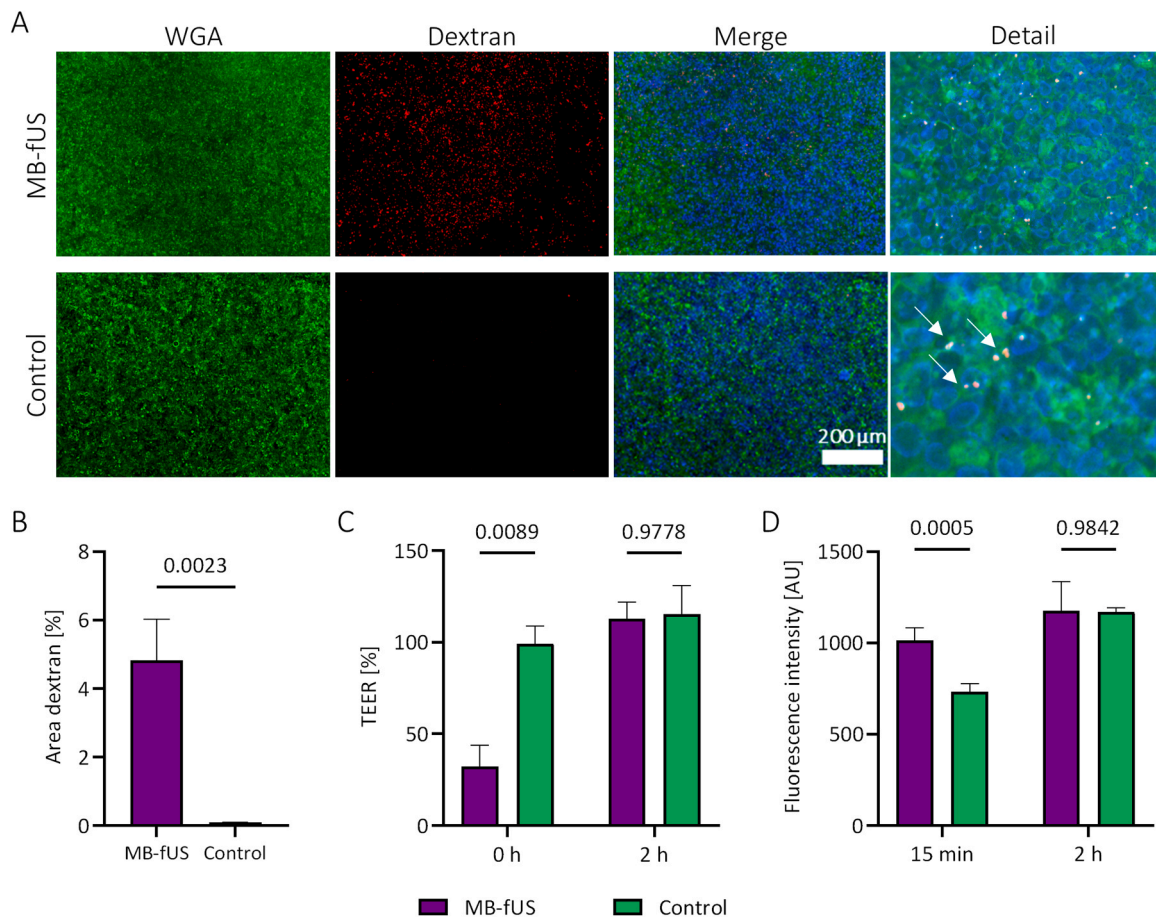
In vitro* sonoporation and sonopermeation of 4T1 monolayers. A. Representative fluorescence images of 4T1 monolayers treated with microbubble-assisted focused ultrasound (MB-fUS) or sham treatment (control) show intracellular Rhodamine B-labeled 70 kDa dextran (red) because of sonoporation. Cell nuclei were visualized with Hoechst (blue) and cell membranes with wheat germ agglutinin (WGA, green). B. MB-fUS treated samples present significantly more dextran incorporated into cells after MB-fUS treatment than sham-treated controls. C. Transendothelial electrical resistance (TEER) is significantly decreased immediately after MB-fUS application as compared to the controls. TEER values appear to restore within two hours. D. MB-fUS treatment results in enhanced diffusion of dextran across the cell monolayer compared to the control group. Reassessment of the diffusion two hours after the treatment shows no significant difference. Data are expressed as mean \pm standard deviation of $n = 3$.
